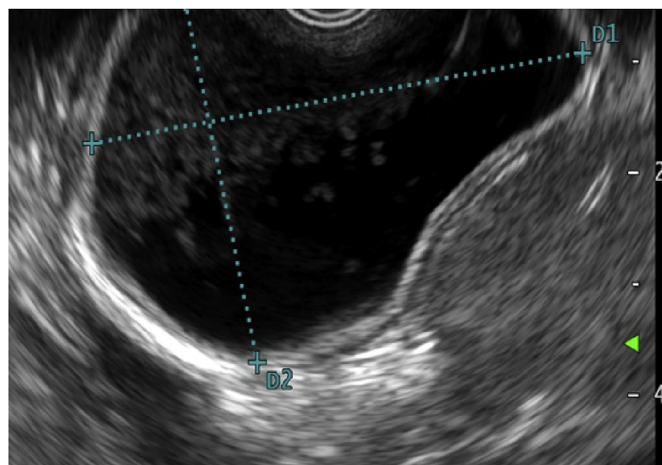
Endoscopic ultrasound image of the cyst.
